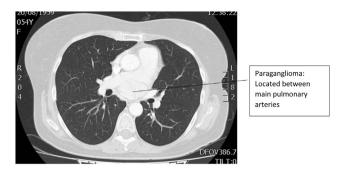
Thoracic CT scan with contrast. Pulmonary window.
